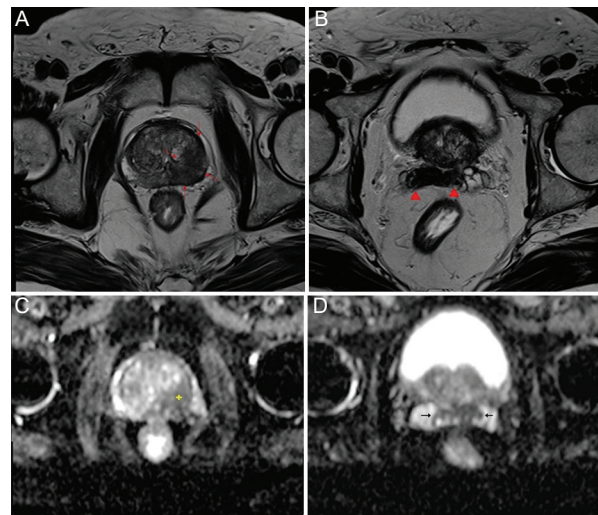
A-D: a 68-year-old male patient. PIRADS 5 lesion involving the anterior and posterior compartments of the middle peripheral zone on the left and involving the transitional zone anterior and posterior zone. The lesion extends to the base of the prostate in more superior sections and invades both seminal vesicles from there. A: T2-weighted image shows signal loss at the described location of the lesion (between the red arrows). B: T2-weighted image, it is observed that the lesion has invaded both seminal vesicles (red arrowheads). C: the apparent diffusion coefficient map, lesion appears hypointense (yellow mark). D: the apparent diffusion coefficient map shows that the lesion has invaded both seminal vesicles (between black arrows).
